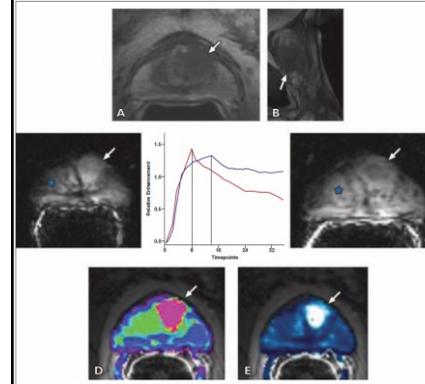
52-year-old man with prostate cancer of central gland, Gleason score 7 (4 + 3) and prostate-specific antigen level of 19.3 ng/ml, who underwent negative transrectal ultrasound prostate biopsy. Endorectal MRI was performed at 3 T for tumor detection. Axial diffusion-weighted image was markedly distorted and nondiagnostic because patient had bilateral hip replacements.
